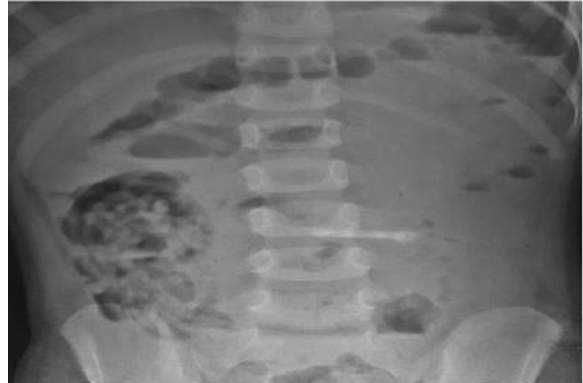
X-ray erect abdomen showing worms in the intestine
